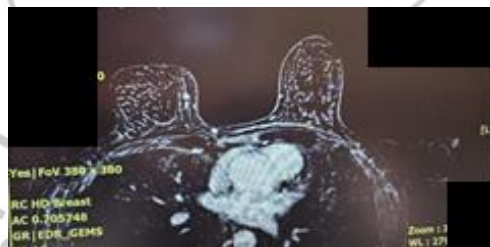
Breast MRI shows lesion with malignant appearance in right breast.
